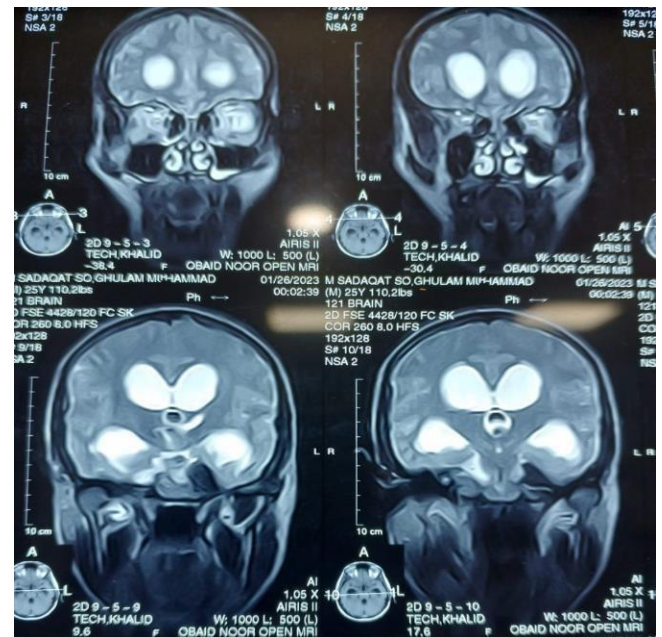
T2 diffusion weighted MRI showing hypo intense lesion in 3rd ventricle.
